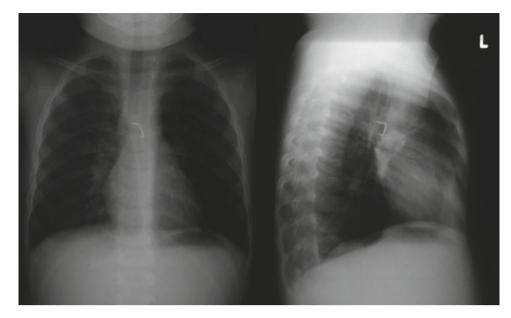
PA and lateral chest X-ray of a child who had aspirated a carpet staple several months prior to presentation. Symptoms included a lingering cough and failure to thrive, but no significant stridor or
